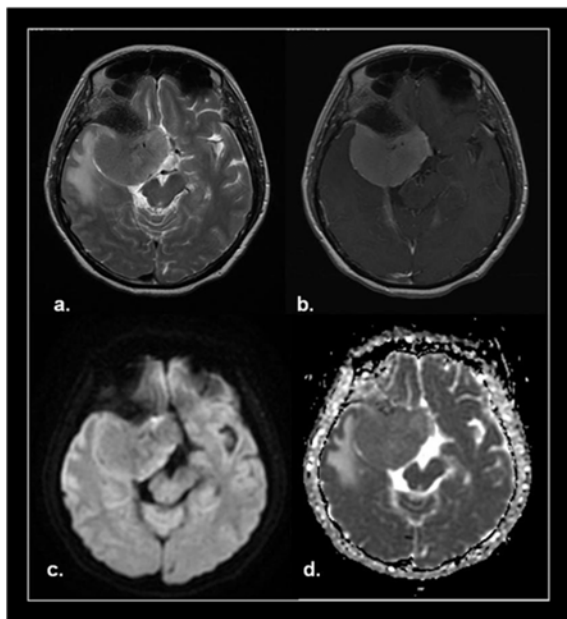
Magnetic resonance imaging scans, with different series, of a 41-year-old woman who had a right sphenoid wing meningioma. Its average apparent diffusion coefficient (ADC) value was 1.39×10^{-3} square millimeter per second. a) T2-weighted image demonstrated hypointensity signal of the tumor. b) Contrast-enhanced T1-weighted image showed, typical for meningioma, vivid enhancement and dural tail sign. c) Restricted diffusion on the diffusion weighted image, d) ADC maps. Operating neurosurgeon categorized this tumor as having hard consistency.
